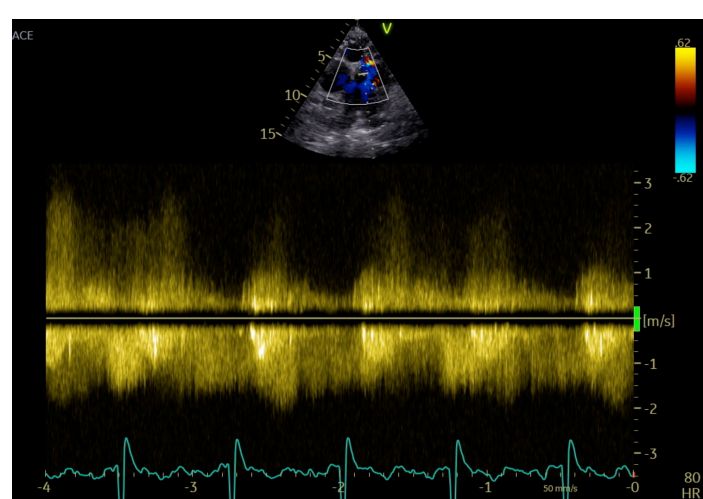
CW doppler showed continuous flow between coronary aneurysms with PA
